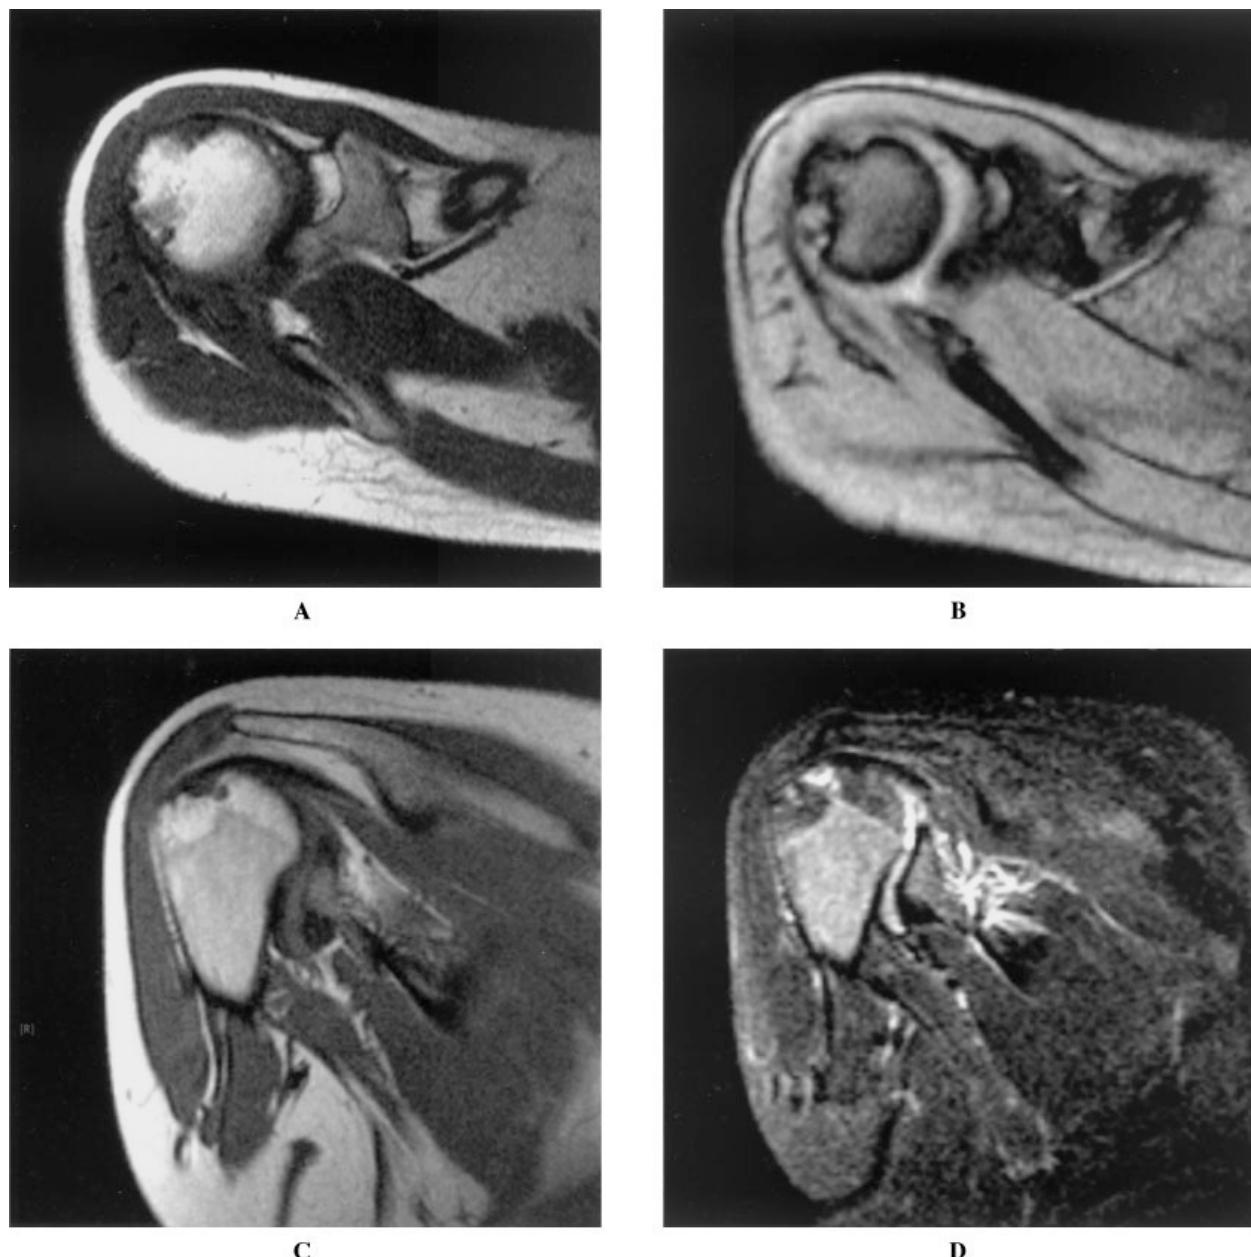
Magnetic resonance imaging of the shoulder joint of the same patient as in Figure 1. In the T1-weighted spin-echo sequence (A) and T2*-weighted gradient-echo sequence (B) in transverse orientation, and in the oblique coronal T1-weighted sequence (C), confluent erosions are evident in the area of the greater tubercle and the adjoining anterior and dorsal portions of the head of the humerus. In the oblique coronal short tau inversion recovery sequence (D), the hyperintense signal of the erosions is an indication of synovitis or effusion.
